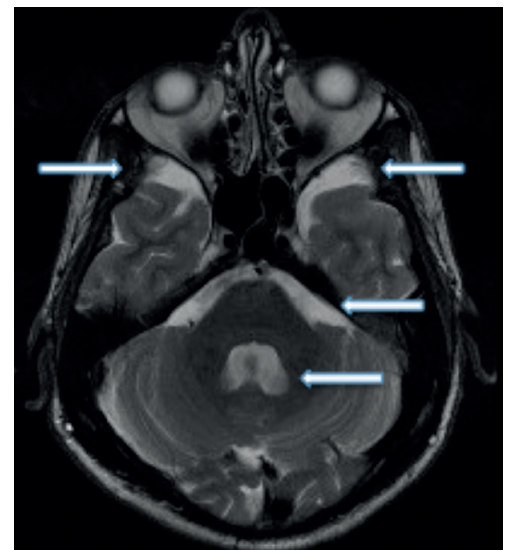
Axial T2-weighted MRI of brain at age 21 (patient 1) demonstrating prominence of CSF spaces for age and bilateral arachnoid cysts anterior to the temporal lobes.
